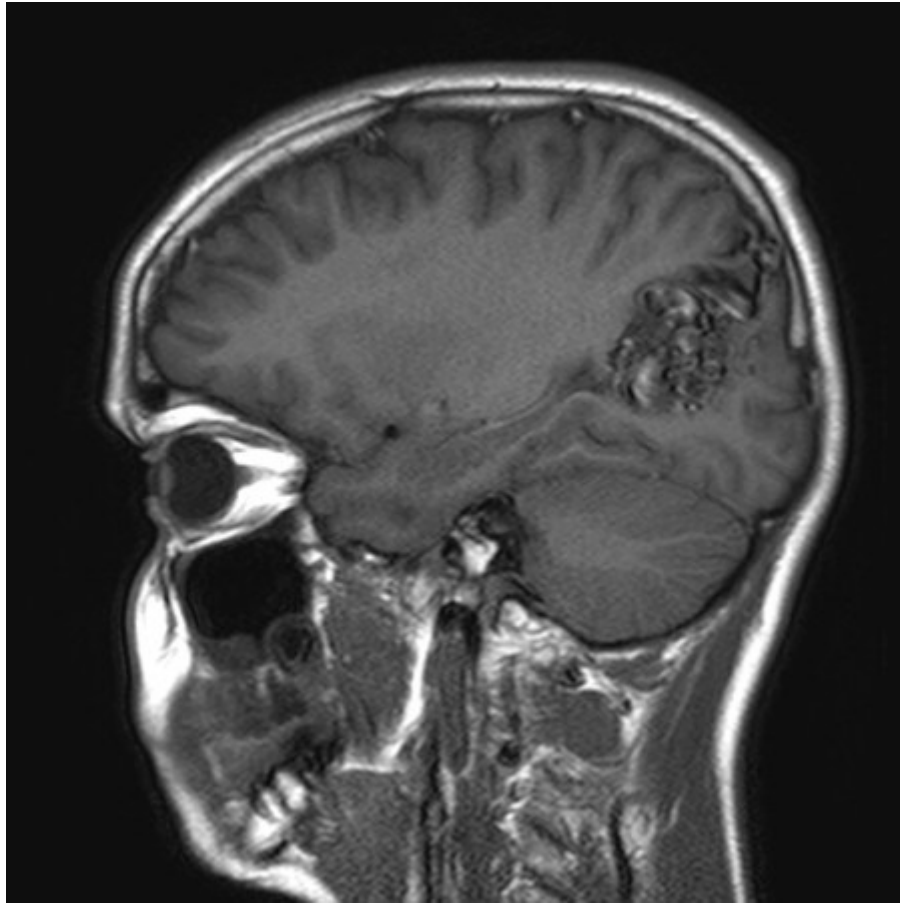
Unruptured left parieto-occipital AVM (sagittal T1-weighted MRI scan)
